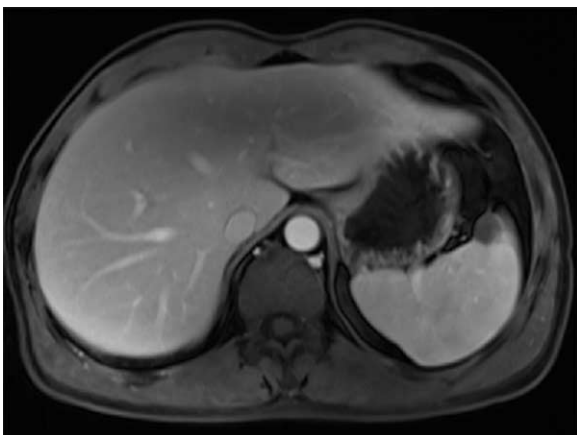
Post-contrast T1WI at portal phase 4 months later after treatment. Spleen shrank to normal size, the nodules seen on previous MRI had been absorbed, and infarction in anterior aspect of spleen also reduced.
